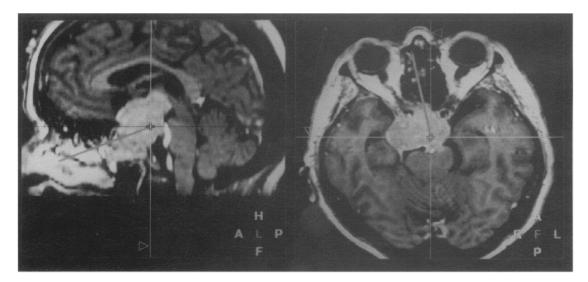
Pointer position in sagittal and axial MR images during mid-facial degloving approach to a large recurrent pituitary tumour. In this particular case, the carotid arteries bilaterally and the basilar artery at the rear aspect of the tumour can be seen clearly in the images, and thus potentially catastrophic vascular injury avoided, as well as the position of the anterior aspect of the brainstem. A more radical resection may be carried out in the confidence of the exact anatomical position of the surgeon's instruments.
